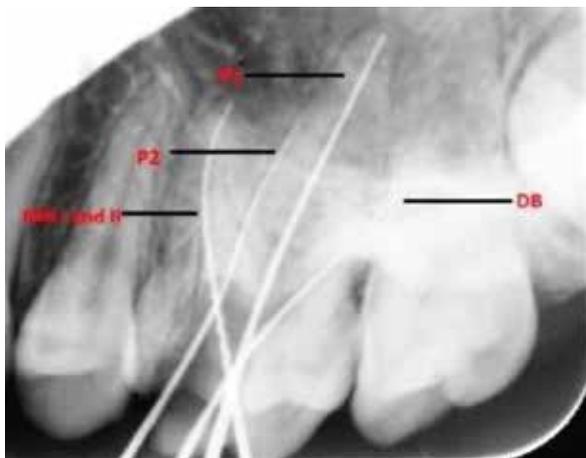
Radiograph showing working length determination.
